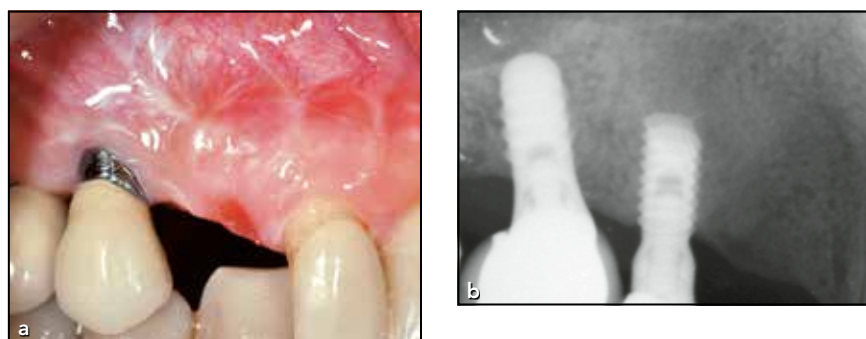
(a) Clinical and (b) radiographic views of the resected implant at the 2-year follow-up.
